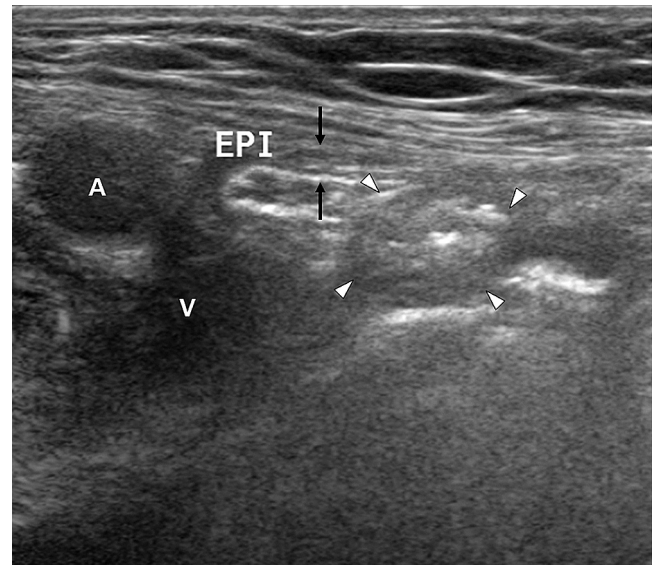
Direct inguinal hernia. Transverse sonogram, showing a large hernia sac with the neck (black arrows) medial to the inferior epigastric artery and paired vein. The hernia sac contains bowel (white arrowheads) with bowel gas. A = femoral artery; EPI = inferior epigastric artery and paired vein; V = femoral vein.
